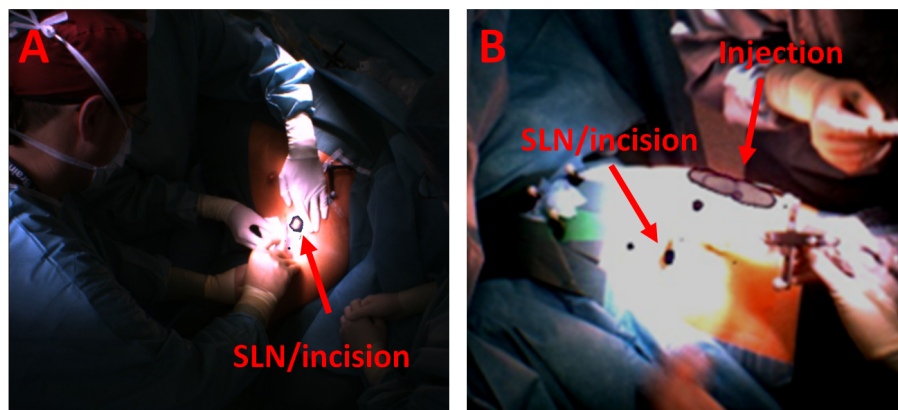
Two examples how incision planning works. In (A) opening of axilla is guided by freehand SPECT image. In (B) the same is done for a node in the side of the abdomen for a patient with melanoma in the back.
